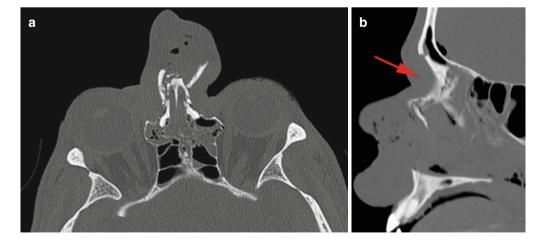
CT imaging is essential to define the extent of this injury (a, b). There is clearly collapse of the nose into the ethmoid sinuses with outward displacement of the canthal regions and medial orbital wall. There is also intracranial air confirming the clinical suspicion of a dural tear. Neurosurgical and ophthalmic opinions should be sought. *Red arrow* indicates the direction of force
